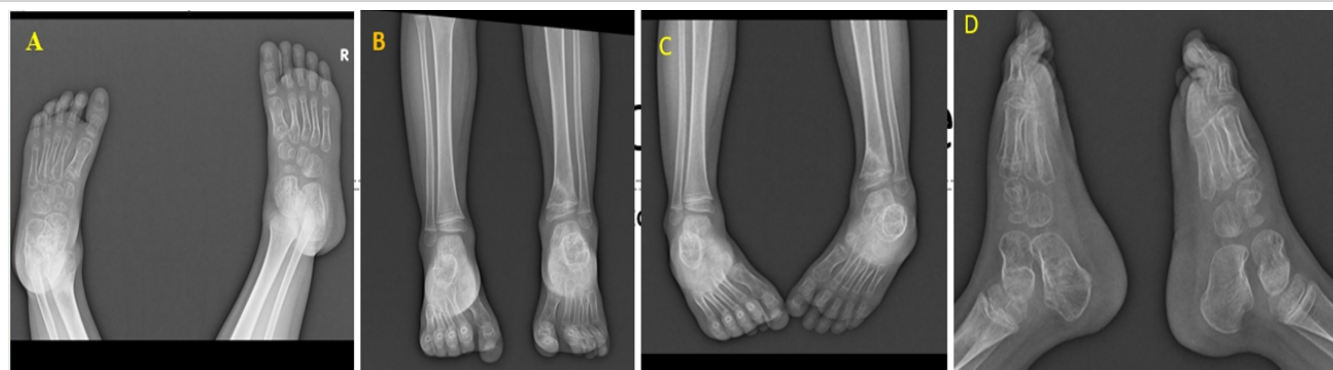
15-months follow-up radiographs of bilateral ankle and foot showing complete union at all fracture sites with no any evidence of avascular necrosis of talus. Antero-posterior views of foot and ankle (A and B), mortise view of bilateral ankle (C) lateral view (D).
